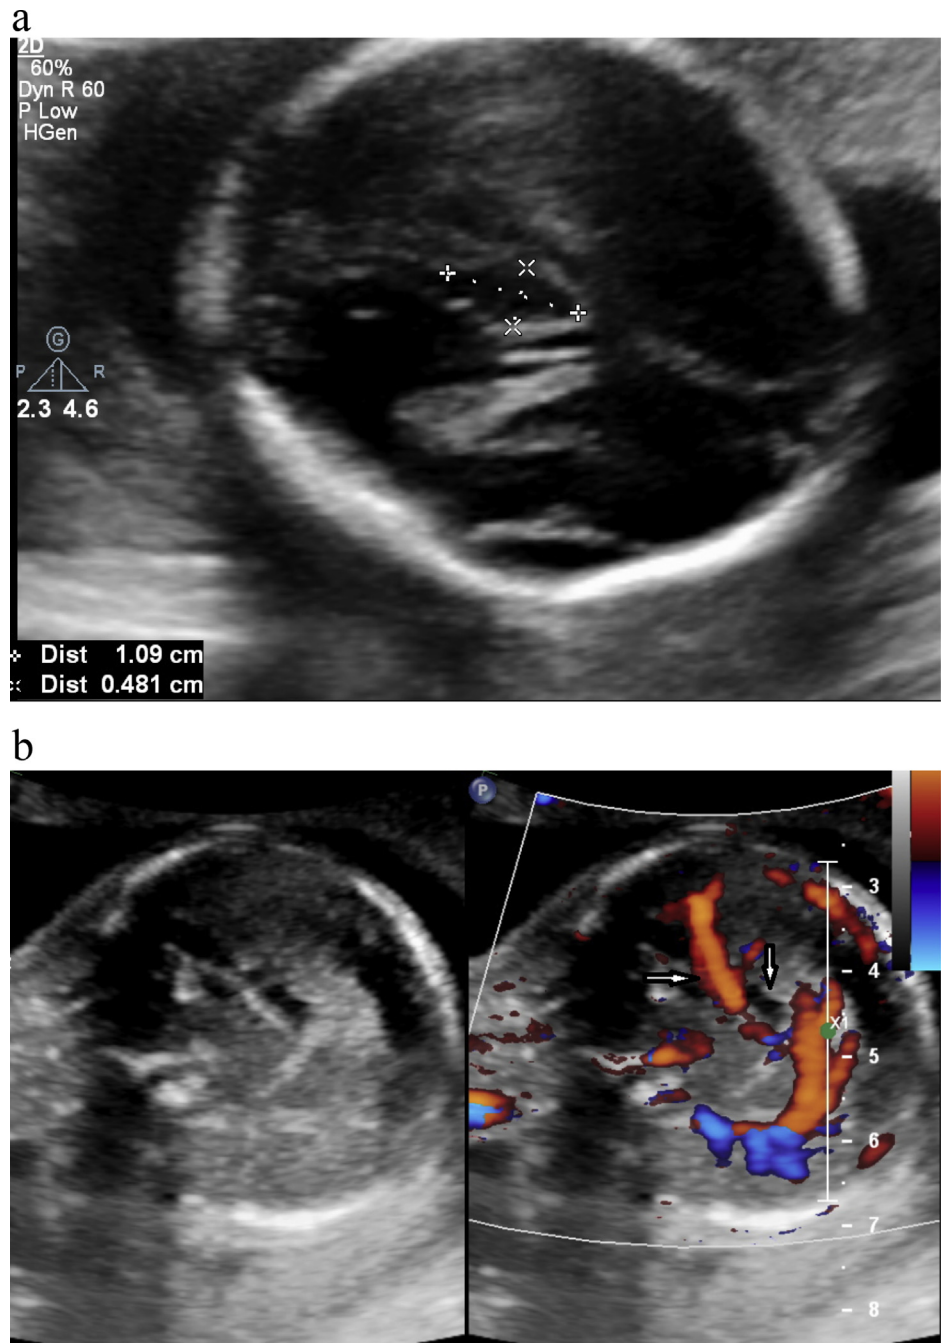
A 20 weeks normal fetuses with a 10 mm Cavum veli interpositi cyst. a: The axial view shows the location of cyst in posterior and separate from cavum septum pellucidum. b: In sagittal view, Color Doppler study shows the internal cerebral vein (horizontal arrow) is located under the cyst (vertical arrow).
